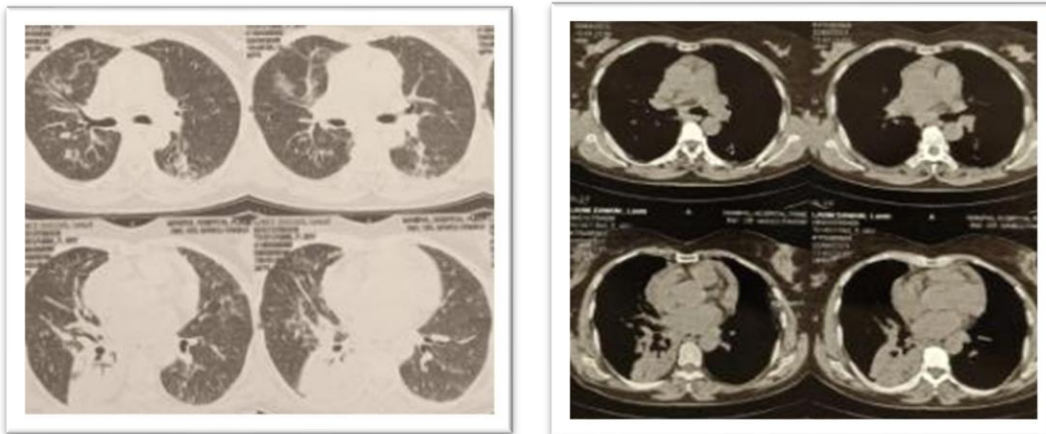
CT scan of chest on February 2023 showing consolidation in the right lower lobe, along with multiple nodular consolidations and enlarged mediastinal lymph nodes
